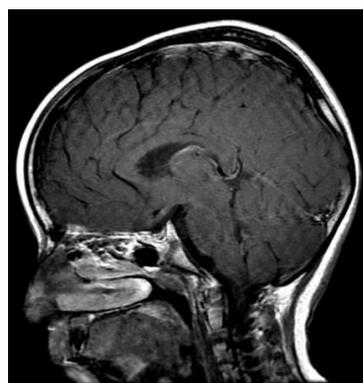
Sagittal T1-weighted image of post-contrast corpus callosum.
